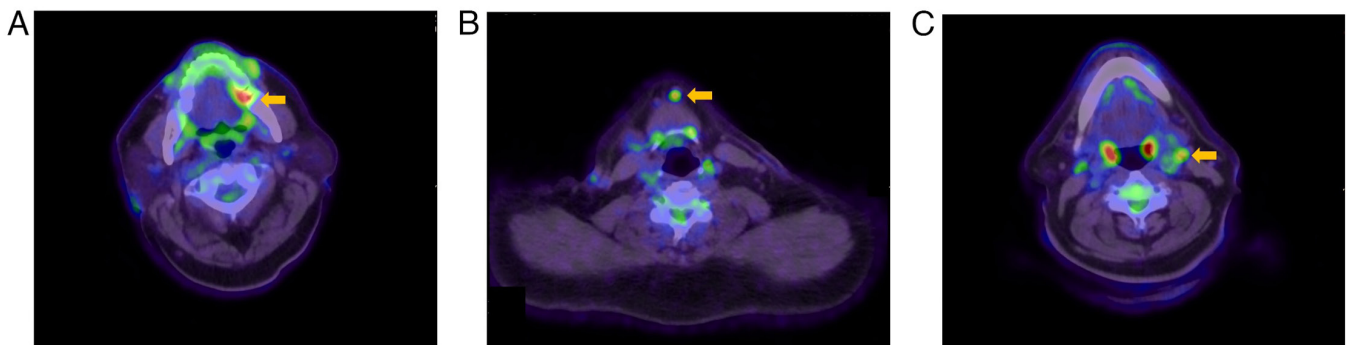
Positron emission tomography/computed tomography images of the neck. (A) Strong FDG accumulation was observed on the left side of the tongue. Abnormal FDG uptake was also seen in the (B) submental and (C) left submandibular lymph nodes.
